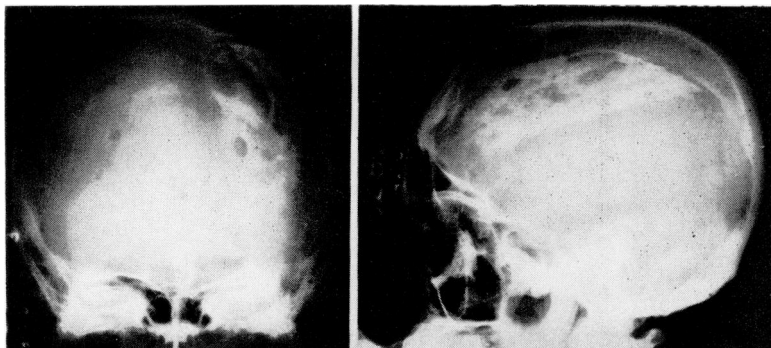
Routine anteroposterior and lateral radiographs of the skull reveal the typical calcific wedge shaped density and skull asymmetry.
